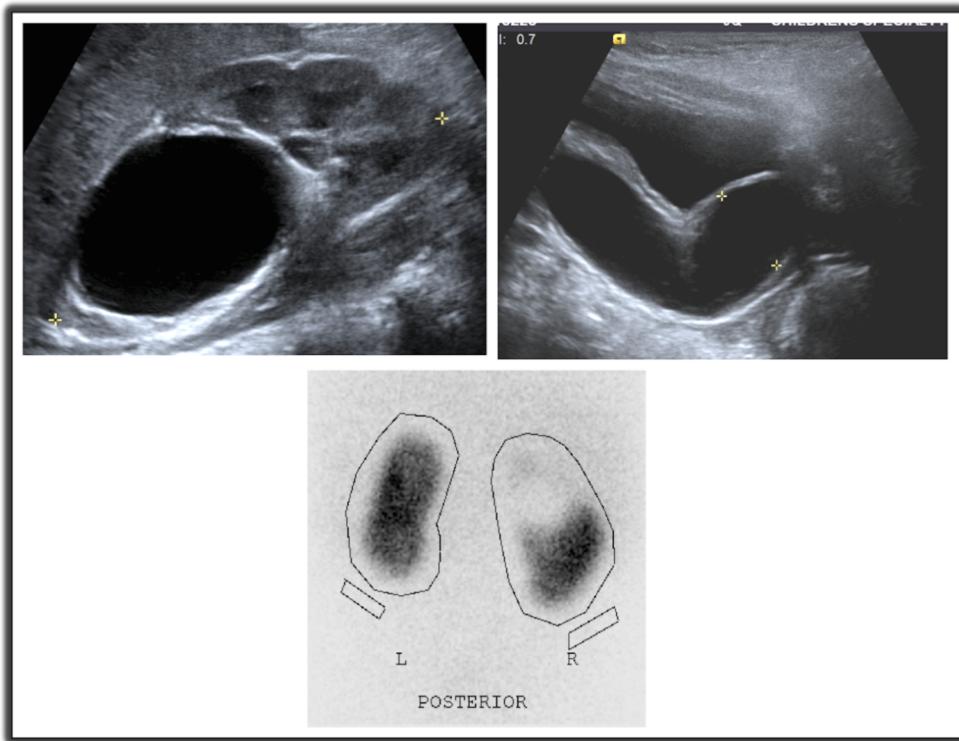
Megaureter. Hydronephrosis in kidney (upper left) and distal ureter (upper right) on ultrasound. Appearance of possible distal aperistaltic segment on retrograde pyelogram (lower left). Delayed drainage on diuretic renography in primary megaureter (lower right).
